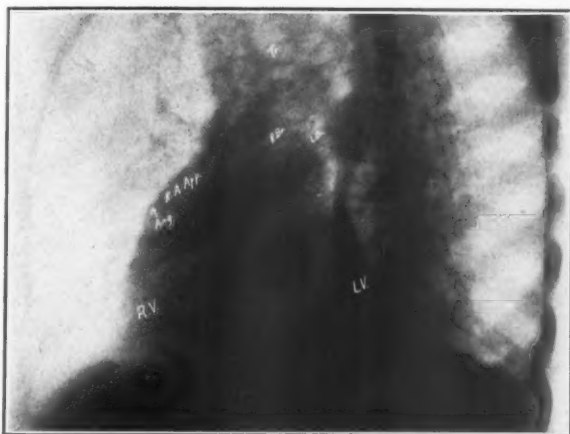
Same case as in Fig. 11. Radiographed in left anterior oblique position. Enlargement of the inflow tract indicated by the prominence of the ventral border of the heart below the angulation. The width of the lower border is increased.
